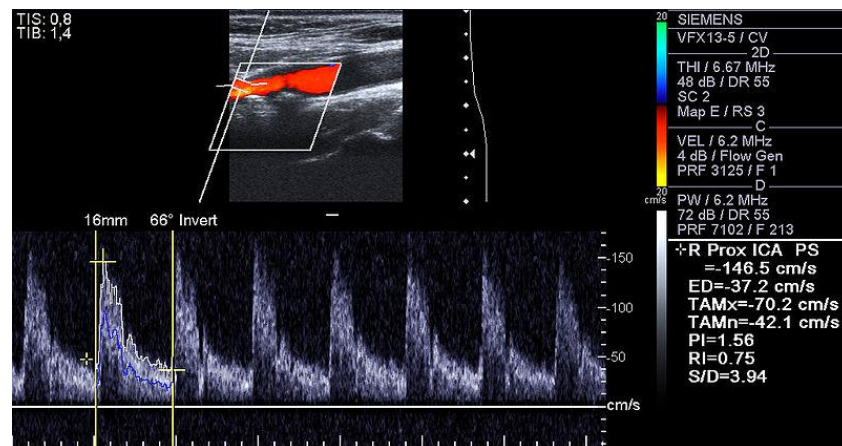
Doppler ultrasound of right internal Carotid artery showing about 70% stenosis due to plaques formation.
